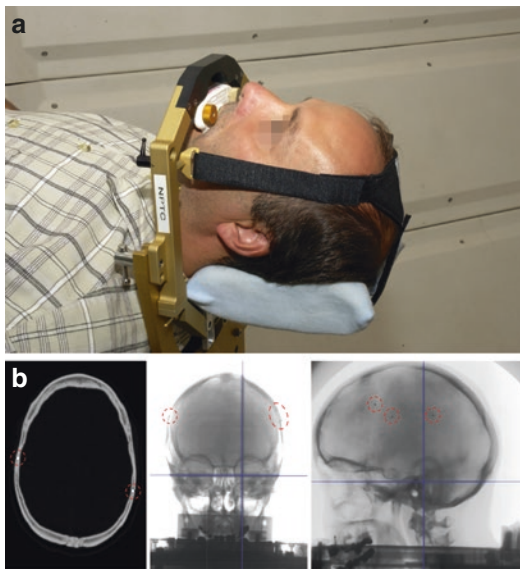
Proton treatment immobilization and localization. (a) The modified Gill-Thomas-Cosman mask achieves reproducible noninvasive immobilization with a Velcro strap that secures the patient's forehead and a custom dental tray that rigidly associates with his/her dentition. (b) Fiducials are placed via a minimally invasive procedure deep to the outer table of the calvarium. CT (left panel) demonstrates well-placed fiducials (red circles). Pretreatment onboard kV imaging (middle and right panel) sets the isocenter by aligning to fiducials (red circles) with ± 0.5 mm accuracy
